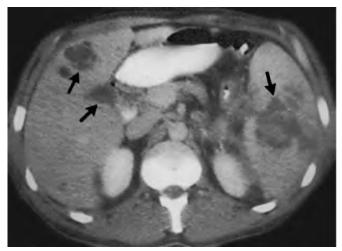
Computed tomography scan of a patient with laboratory-acquired glanders showing abscesses (arrows) in the liver and spleen. (From Srinivasan A, Kraus CN, DeShazer D, et al. Glanders in a military research microbiologist. N Engl J Med. 2001;345:256–258.)
